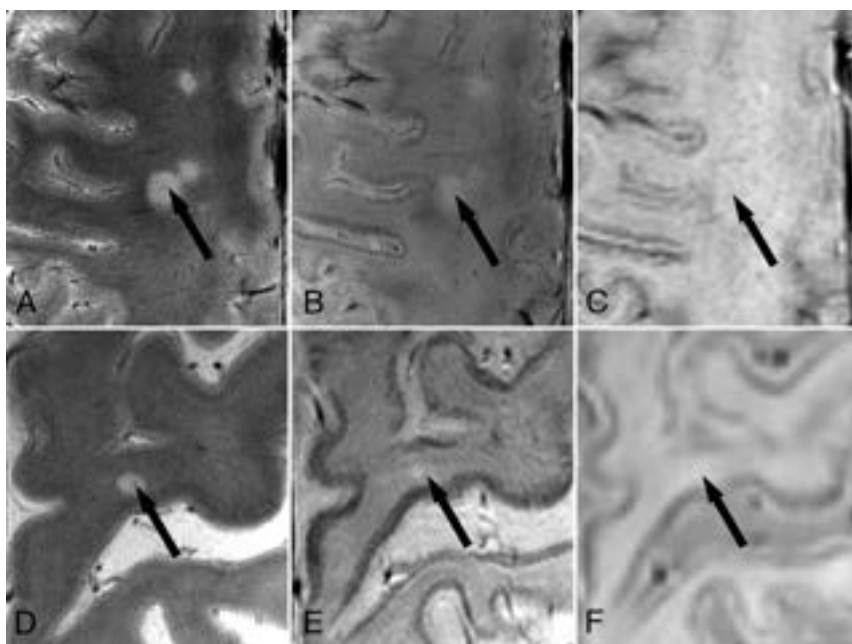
CVS by MRI field strength. A, 7T T2* shows a subtle central vein (arrow) that is not well seen on (B) 7T SWI or (C) 3T SWI. D, 7T T2* shows a central vein (arrow) in a small subcortical lesion that is not well seen on (E) 7T SWI or (F) 3T SWI.
